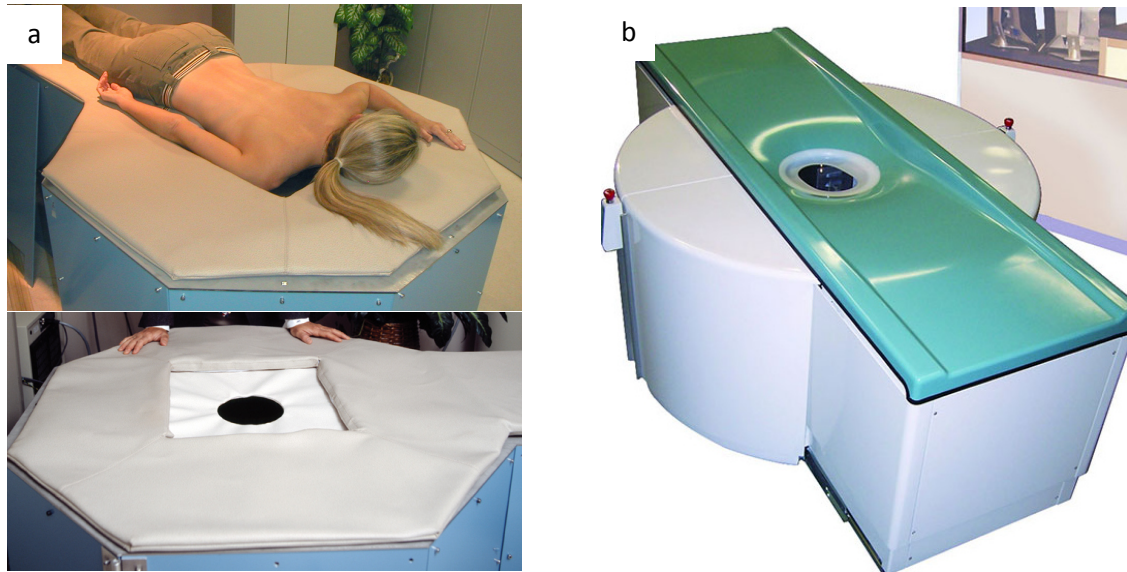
Flat breast screening systems: (a) UC Davis Breast CT Project, and (b) Koning™ Breast CT
